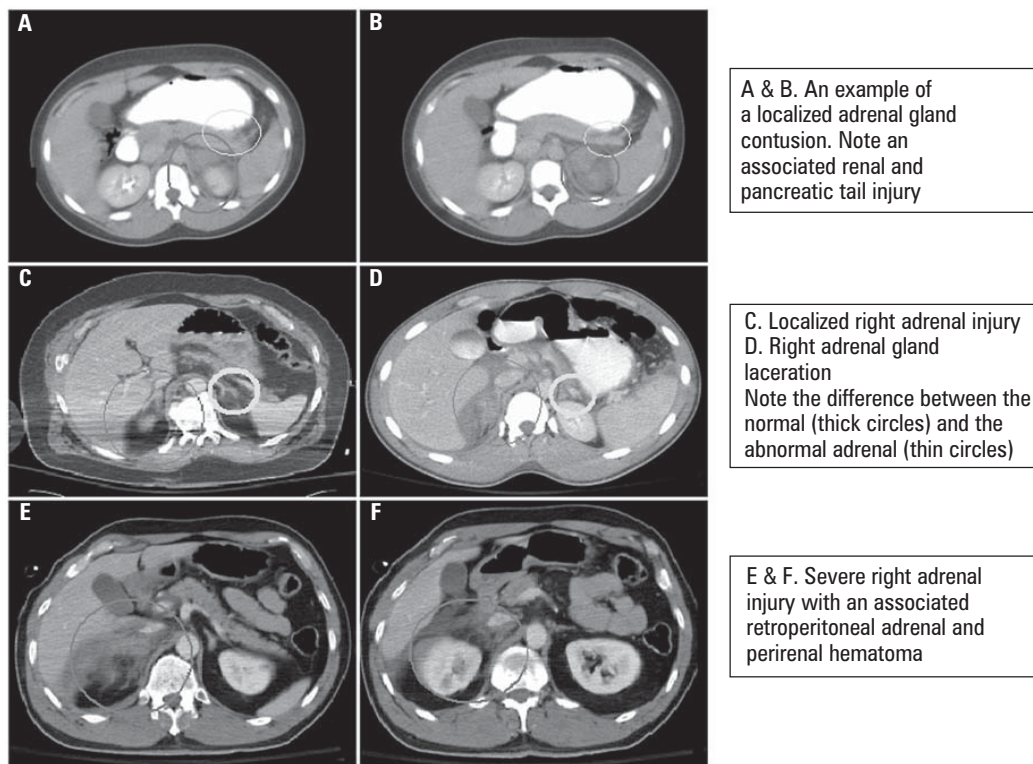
Examples of three different types of adrenal gland injuries (AGI) classified by computed tomographic (CT) appearance: (A–C) Adrenal gland contusion; (D) Adrenal gland laceration; and (E–F) Adrenal gland injury associated with large retroperitoneal hematoma
